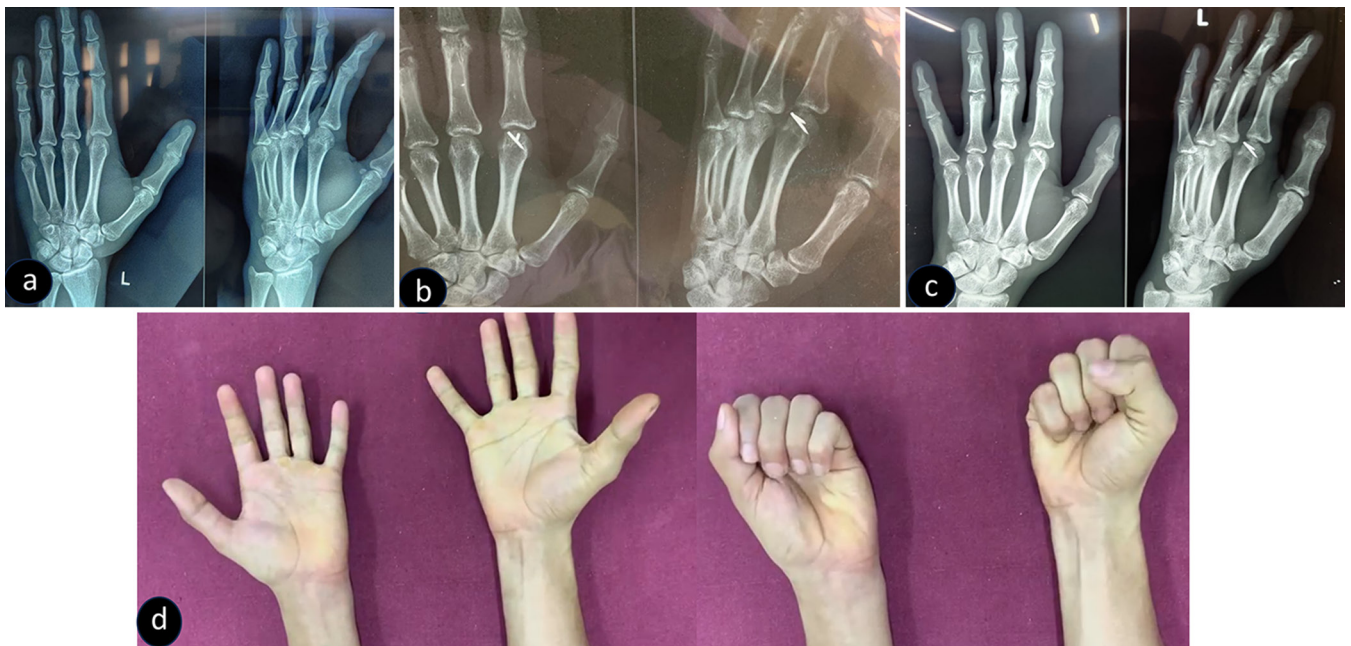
(a) Radiograph showing second metacarpal head fracture with a sliver of bone (associated with extensor tendon and capsule injury). (b) Immediate post-operative radiograph showing fracture of 2nd metacarpal head fixed with crimped wires. (c) One-year follow-up radiograph showing healed fracture with no wire penetration into the joint. (d) One-year follow-up clinical picture showing a good range of movement at the metacarpophalangeal joint.
